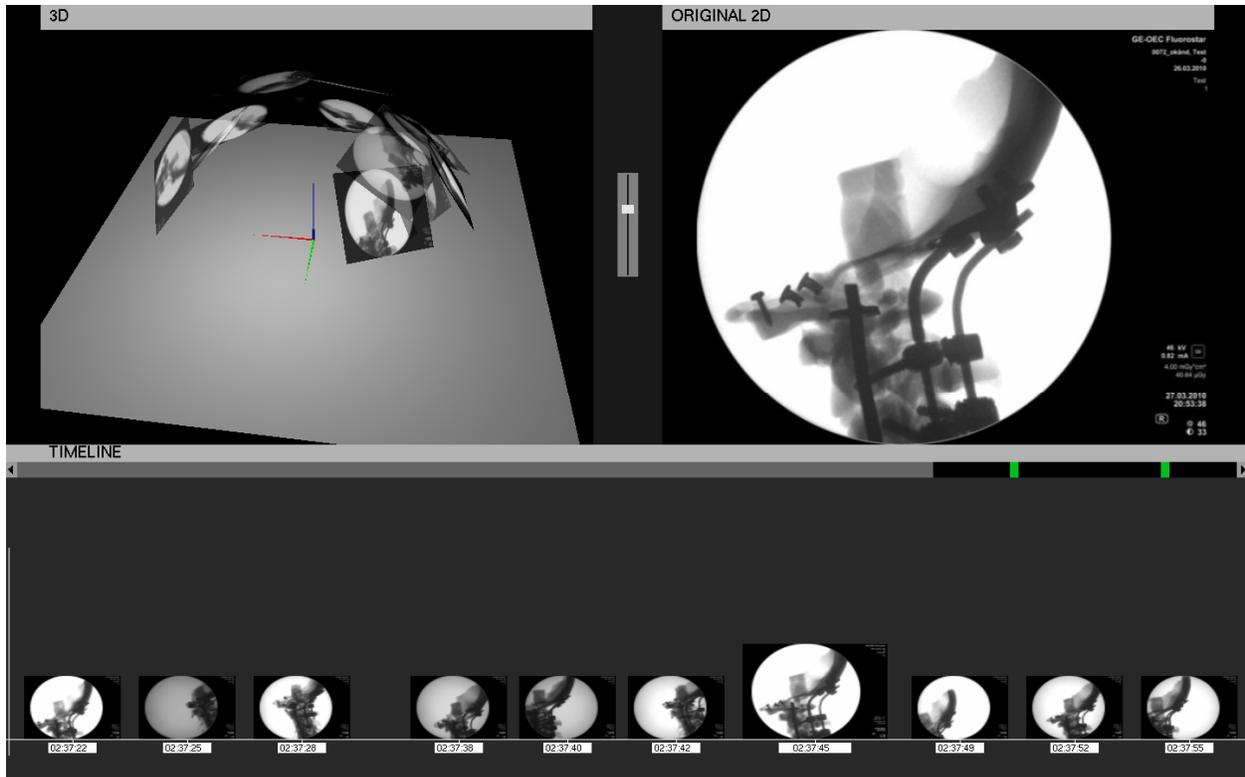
The user interface provides three views of the acquired X-ray imagery. 3D view (top left): A 3D cloud where each X-ray is positioned and oriented based on the fluoroscope’s alignment at the acquisition time. The user can change the perspective through rotation, pan and zoom. Original 2D view (top right): A full-resolution view of an X-ray that has been activated from the 3D or Timeline view. Timeline view (bottom): The acquired X-rays are arranged in an interactive timeline. Green markers on scrollbar indicate locations with additional images that are outside the current view (grey part of scrollbar).
